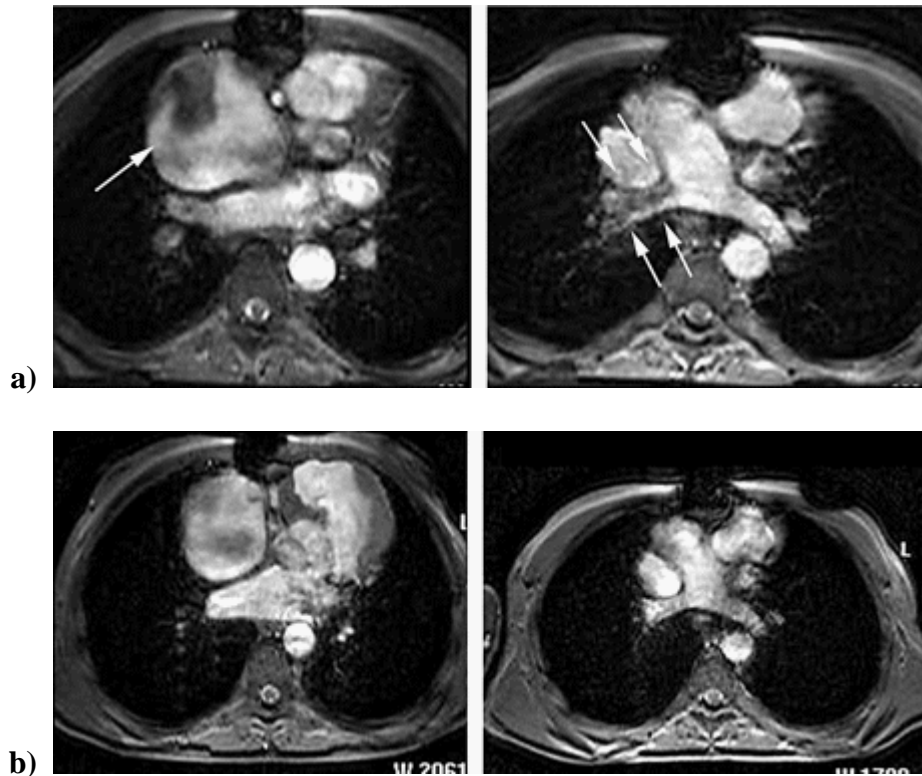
Cine magnetic resonance images of a right atrial mass with low signal
